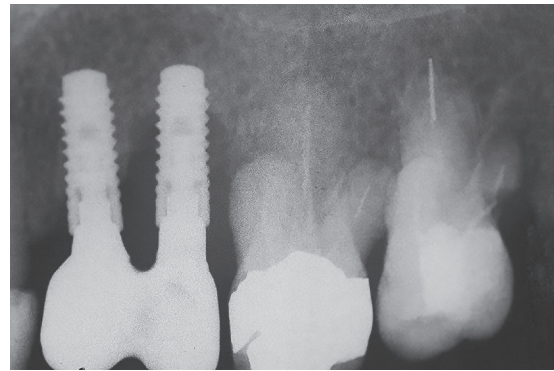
Initial dental X-ray indicated bone lost surrounding the implant 25.
